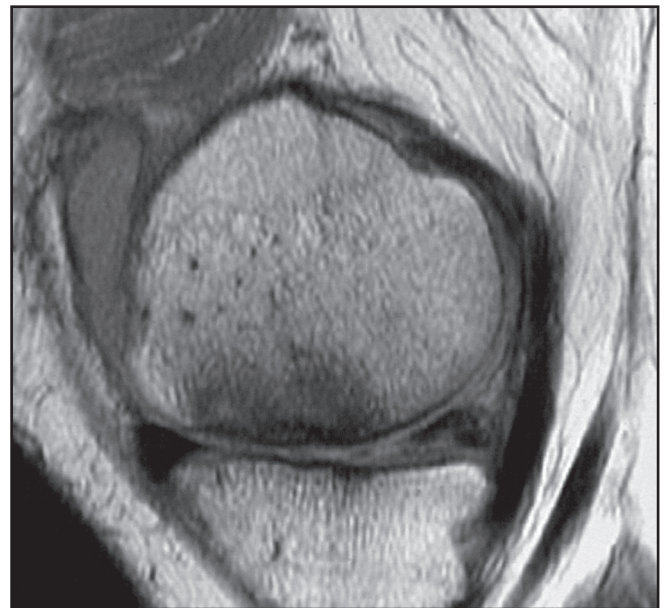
Magnetic resonance image showing idiopathic osteonecrosis of the medial femoral condyle and medial meniscus injury.
